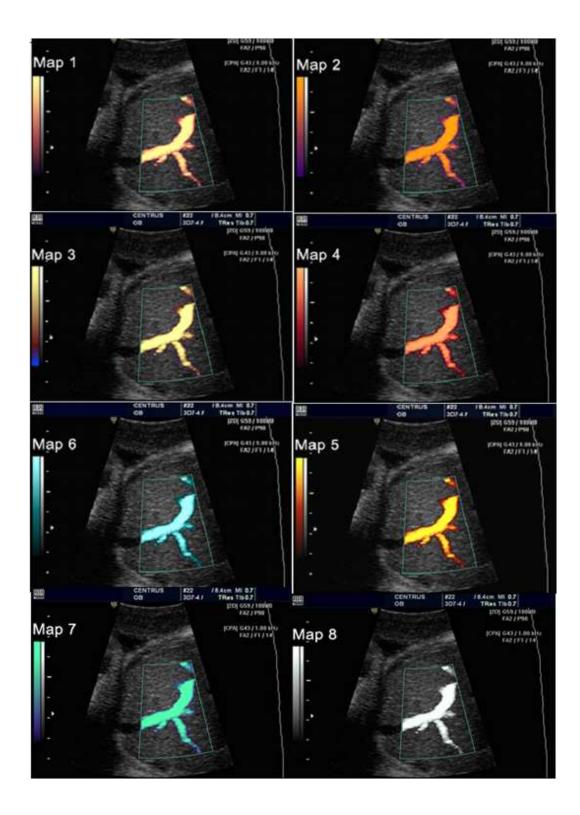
Color power energy Doppler (amplitude flow
